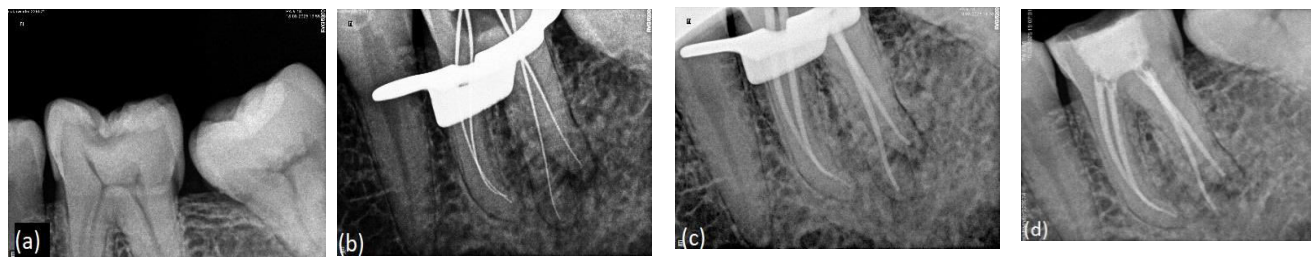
(a) Pre Operative Radiograph of 36. (b) Working Length Radiograph of 36. (c) Master Cone Radiograph of 36. (d) Postoperative Radiograph of 36
